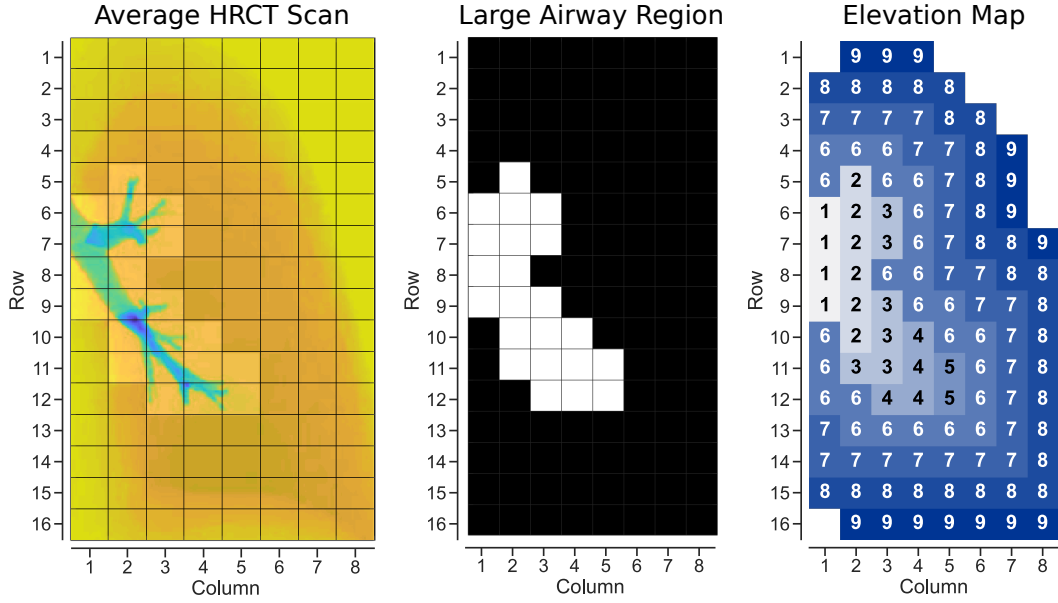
Process of generating flow constraints. 2D projection of HRCT scan from [44] was divided into a 16 x 8 grid (left). Grids containing visible large airways were selected to define a large airway region (LAR), shown as a black and white mask in the middle panel. Inside the LAR, elevation was defined as the city-block distance to the trachea, located at the left edge. Outside the LAR, it was defined based on the city-block distance to the LAR (right). Flow between grids was constrained, so that mucus could only flow to neighboring grids of equal or lower elevation.
